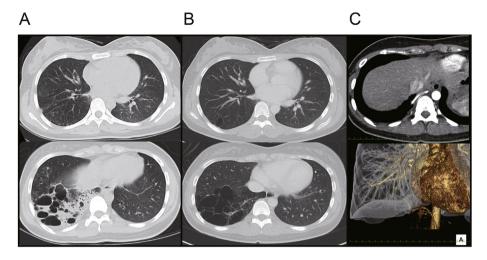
High-resolution CT of the thorax and CT angiography. (A) Chest CT on admission. The chest CT shows complex cystic lesions with a high air-fluid level in the right lower lobe and diffuse nodular shadows in the whole lobe of the lung. (B) Chest CT after 6-month administration of clarithromycin. Reductions in both diffuse nodular shadows and the fluid in the cystic lesions are observed. (C) CT angiography after 6-month administration of clarithromycin. The CT angiography demonstrates an aberrant systemic artery arising from the celiac trunk and supplying the cystic mass lesions with systemic blood flow.
